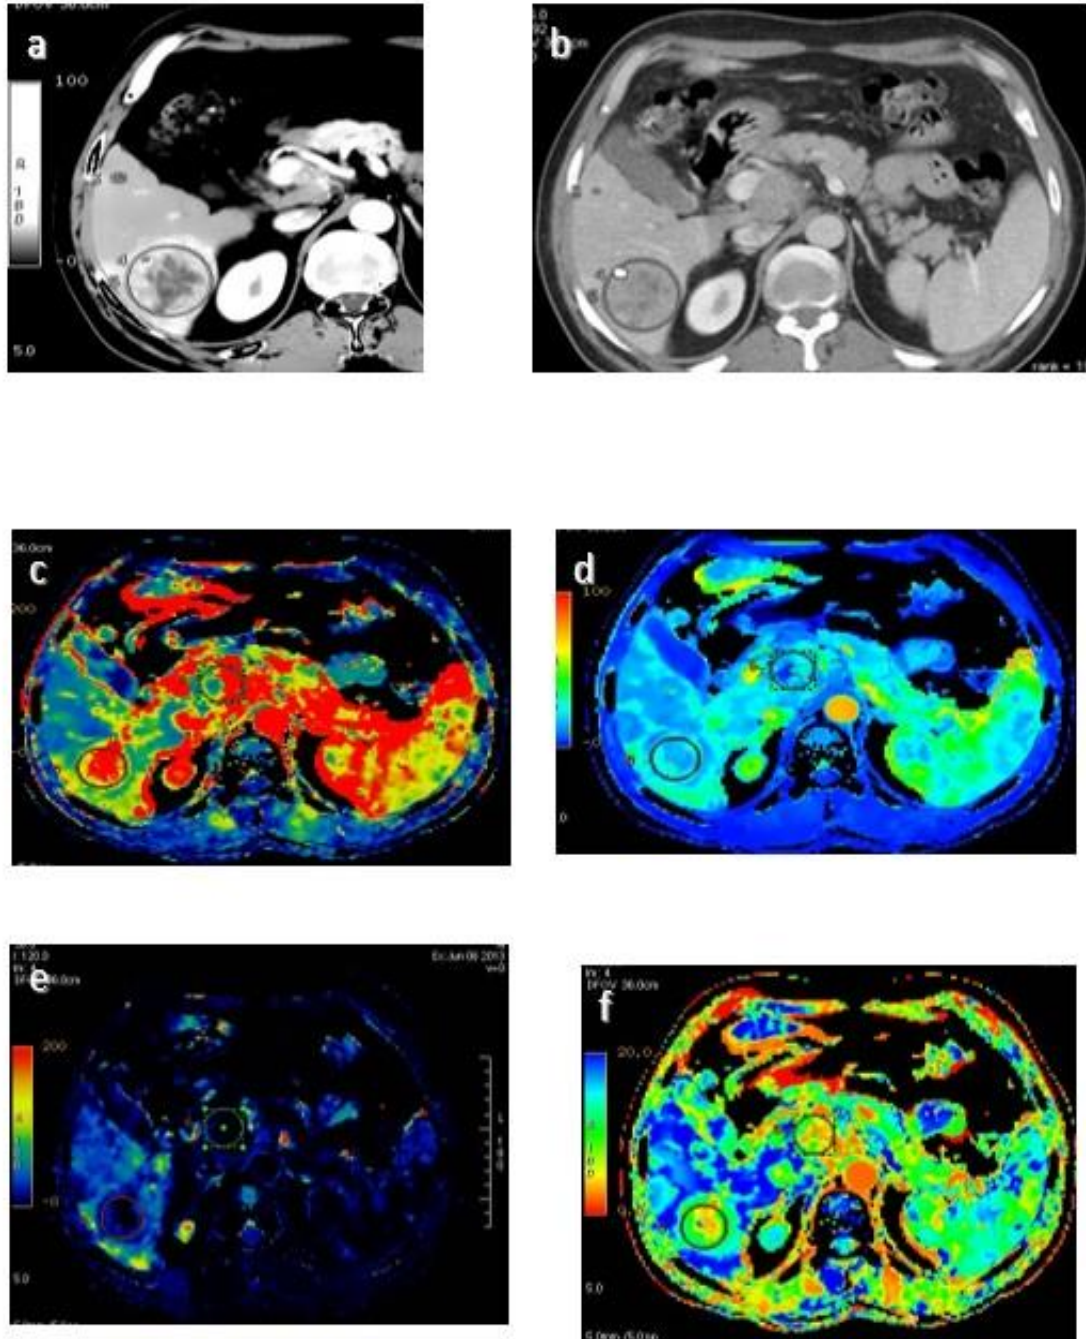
Hepatic focal lesion diagnosed as hepatocellular carcinoma by biopsy. (a) The arterial phase of postcontrast CT showed early enhancement of the lesion. (b) the portal phase of postcontrast CT showed a washout of the contrast. (c) BV map. (d) BF map. (e) PS map. (f) MTT map. BV, BF, PS, and MTT of the hepatic focal lesion were 26.71, 660.9, 18.32, and 2.36, respectively. BV, BF, PS, and MTT of the background liver were 23.80, 100.7, 60.9, 4.3, and 14.9, respectively.
